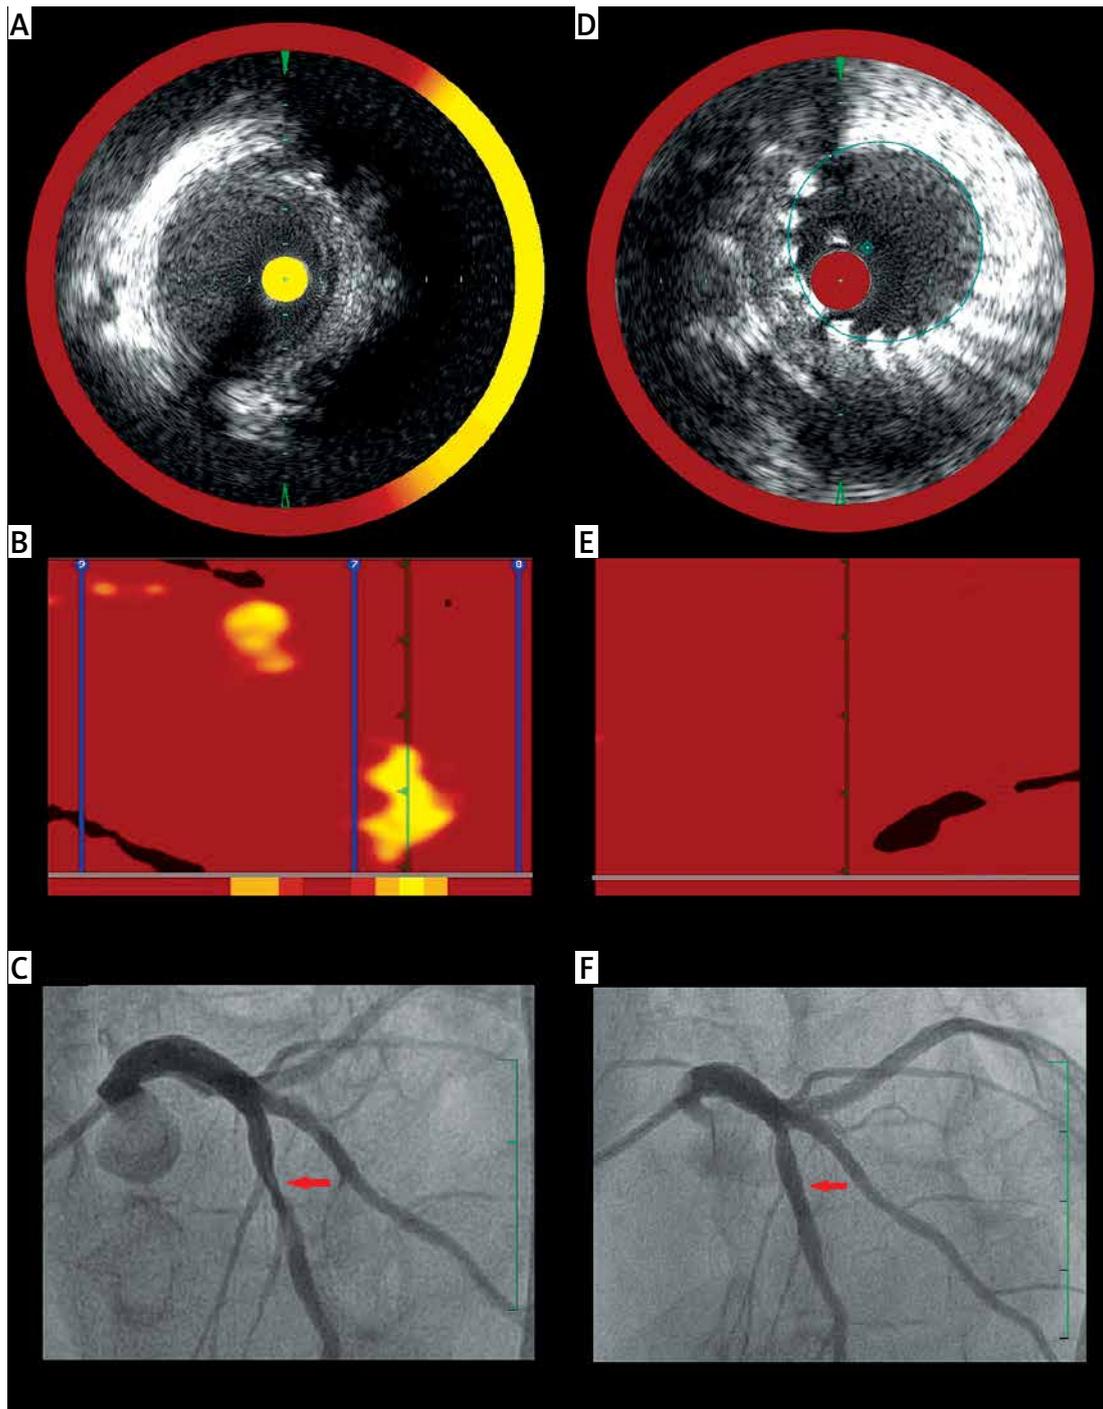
Panel A reveals the intravascular ultrasound (IVUS) image of a lesion in the left anterior descending artery prior to percutaneous coronary intervention (PCI). The near-infrared spectroscopy (NIRS) chemogram obtained before PCI reveals two lipid cores (B). A coronary angiogram of the lesion is provided (C). A second IVUS image acquired after the PCI shows good apposition of the stent (D). The second NIRS chemogram documented complete disappearance of the lipid cores during the dilation of the lesion (E). A good angiographic result is shown in panel F
